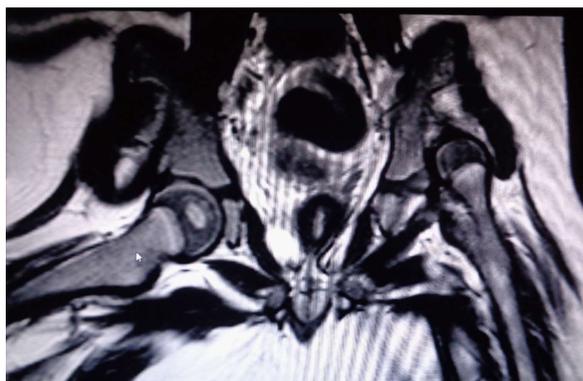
Magnetic resonance imaging of a two-year-old girl with developmental dysplasia of the hip.
